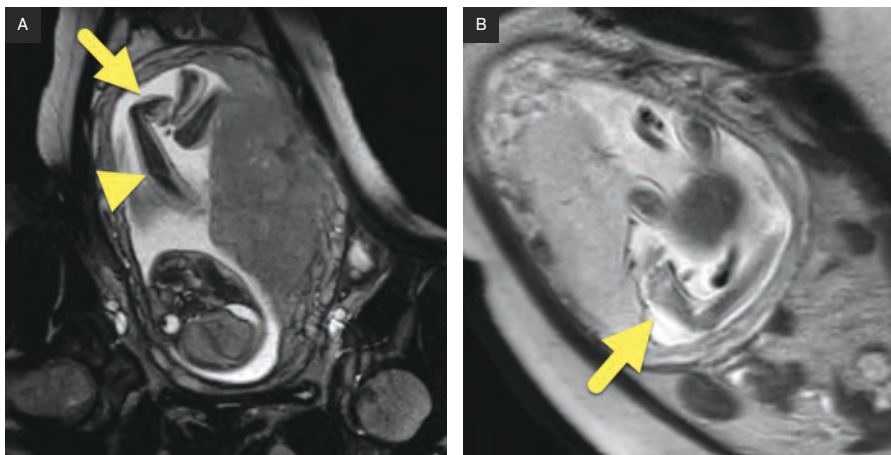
Fetal MRI performed at 25 weeks of gestational age showing (A) fixed extension of the elbow (arrowhead) and flexion of the wrist (arrow). (B) Imaging of the left lower extremity showing a club foot (arrow).
